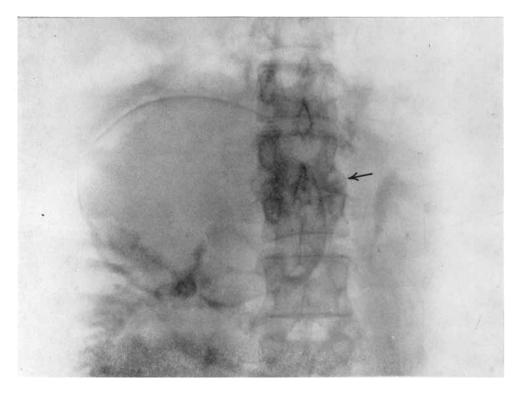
CASE 1. X-ray photograph taken 15 minutes after intravenous injection of Uroselectan B. There is no excretion of dyc into the right renal tract. The arrow indicates the site of a healed tuberculous lesion of the lumbar spine.
